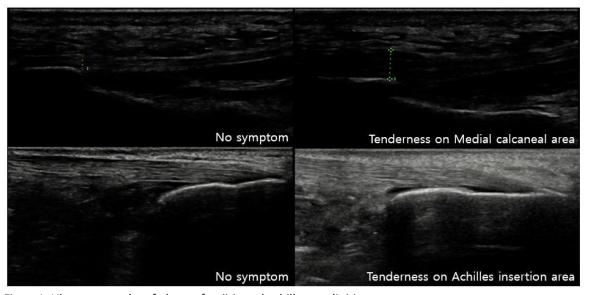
Ultrasonography of plantar fasciitis and achilles tendinitis
